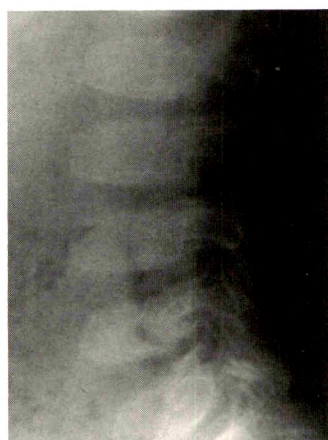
Deferoxamine-induced bone dysplasia in a 7-year-old boy with thalassemia major who had been on combined transfusion-chelation therapy for 5 years and had received a total of 48 units of RBCs. Serum ferritin level was 4068 ng/ml. Lateral radiograph of lumbar spine shows flattening of vertebral bodies. Metaphyseal irregularities were present in long bones (not shown). (Reprinted from Brill et al. [13].)
